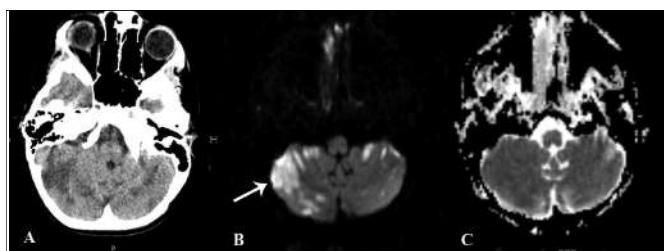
(A) Initial CT scan revealed hypoattenuating areas in bilateral cerebellar hemispheres which were suggestive of ischemic infarcts (B) MRI showed high signal in the cerebellar hemispheres on DWI (C) (white arrow) without any significant dropout on ADC maps.
